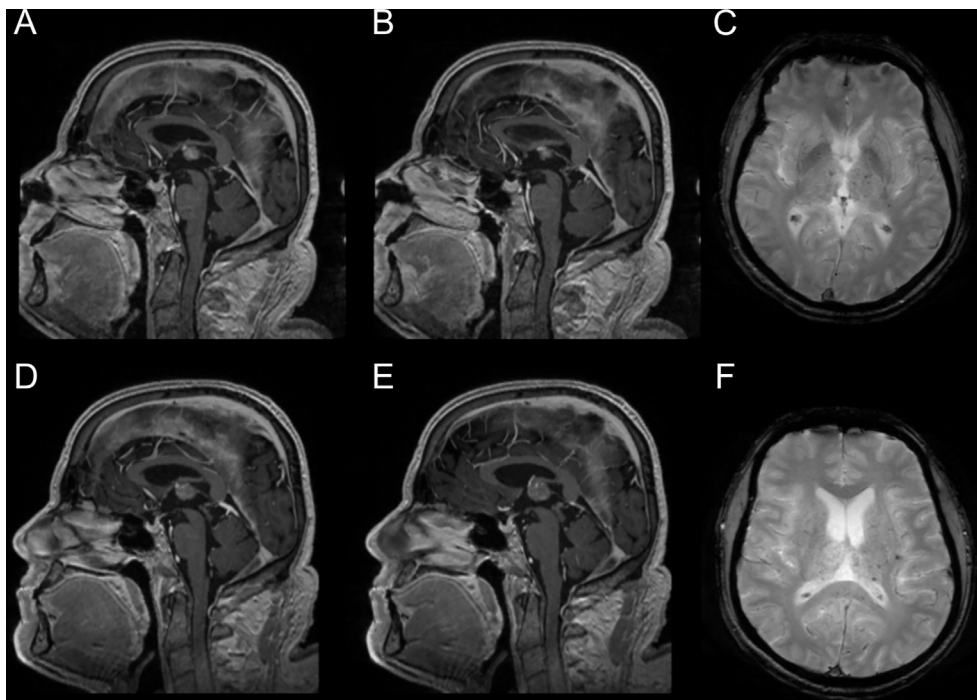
MRI series prior treatment Preoperative MRI on sagittal T2 showing early contrasting of the straight sinus (A–B) and microbleedings bithalamic and at the corpus callosum in T2^w (C). 9 days later early contrasting of the anterior third part of the straight sinus. The posterior part of the straight sinus is thrombosed (D–E). Microbleedings and bithalamic edema in T2^w (F).
